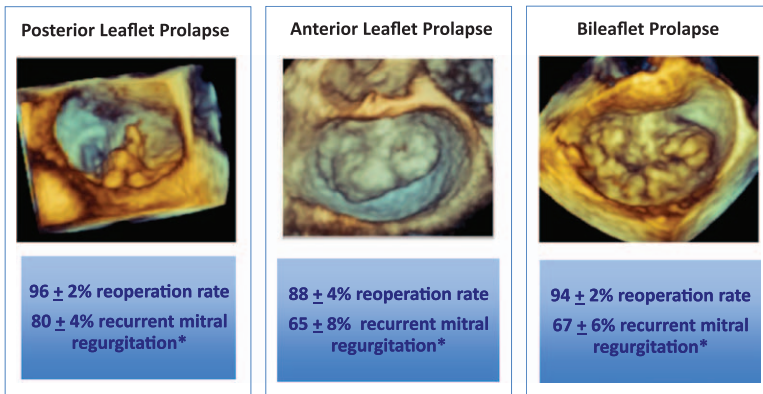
Freedom from reoperation and recurrent moderate or severe mitral regurgitation at 12 years by lesion type. Three-dimensional echocardiographic images demonstrating posterior, anterior, and bileaflet mitral valve prolapse (top, left to right). With increasingly complex mitral valve pathology ranging from posterior leaflet prolapse to anterior leaflet prolapse to bileaflet prolapse, 12-year freedom from reoperation and recurrent moderate or severe mitral regurgitation decreases, as demonstrated with data from David et al.³⁷
